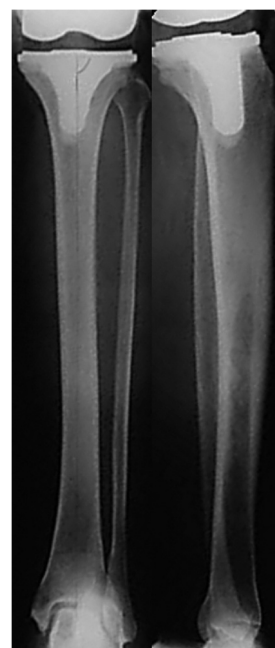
Radiographs in anteroposterior view.
